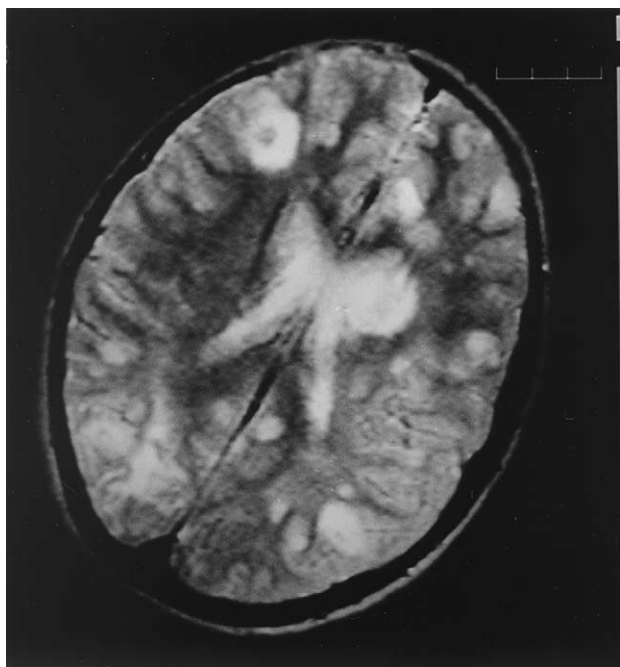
Patient 1. Axial T₂-weighted image MRI scan without contrast, obtained for the diagnostic determination of acute neurologic deterioration after a corticosteroid course in a 12-year-old male with midface granulomatous lesions. Multiple hyperintense cortico-subcortical lesions involving the entire cerebrum.
